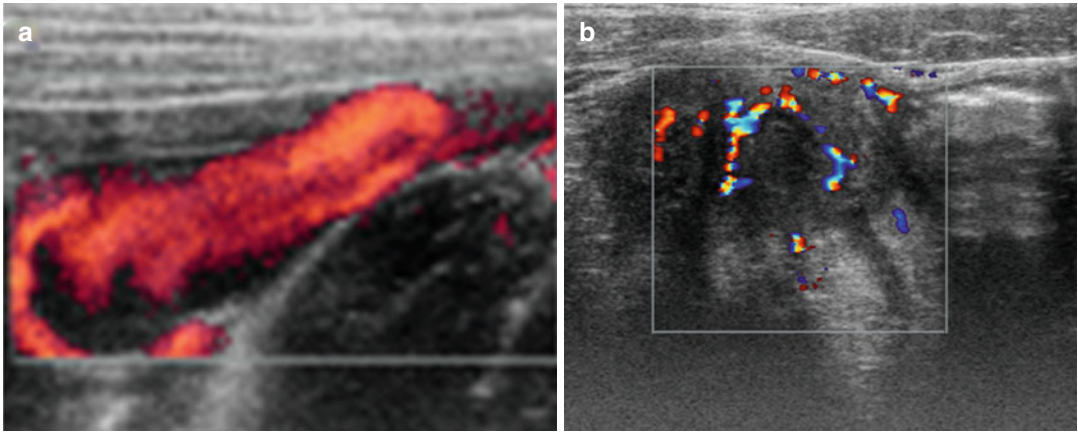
(a, b) The color Doppler US demonstrates peripheral wall hyperemia, reflecting inflammatory hyperperfusion
